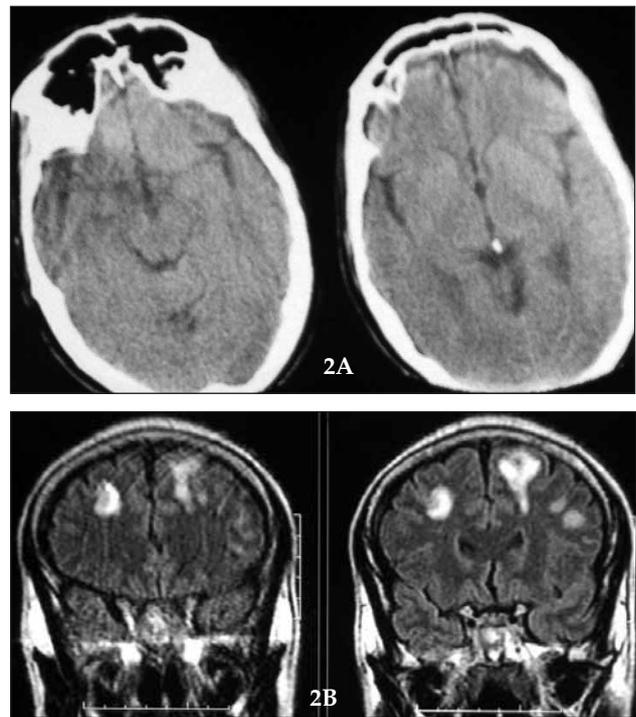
(A) Posttraumatic computed tomography slices show normal appearance of basal cisterns and periventricular area. (B) T1 slices of MRI show multiple settlements of cortical contusions in the same patient.
